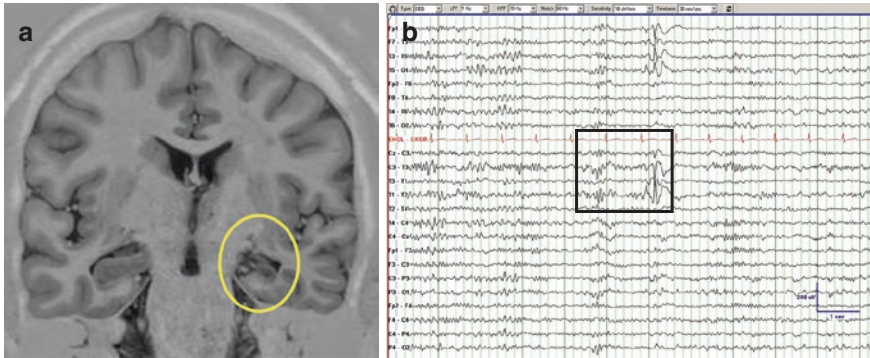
(a) Brain MRI with left hippocampal formation atrophy (yellow circle) and (b) representative interictal EEG showing left temporal spikes (box)
